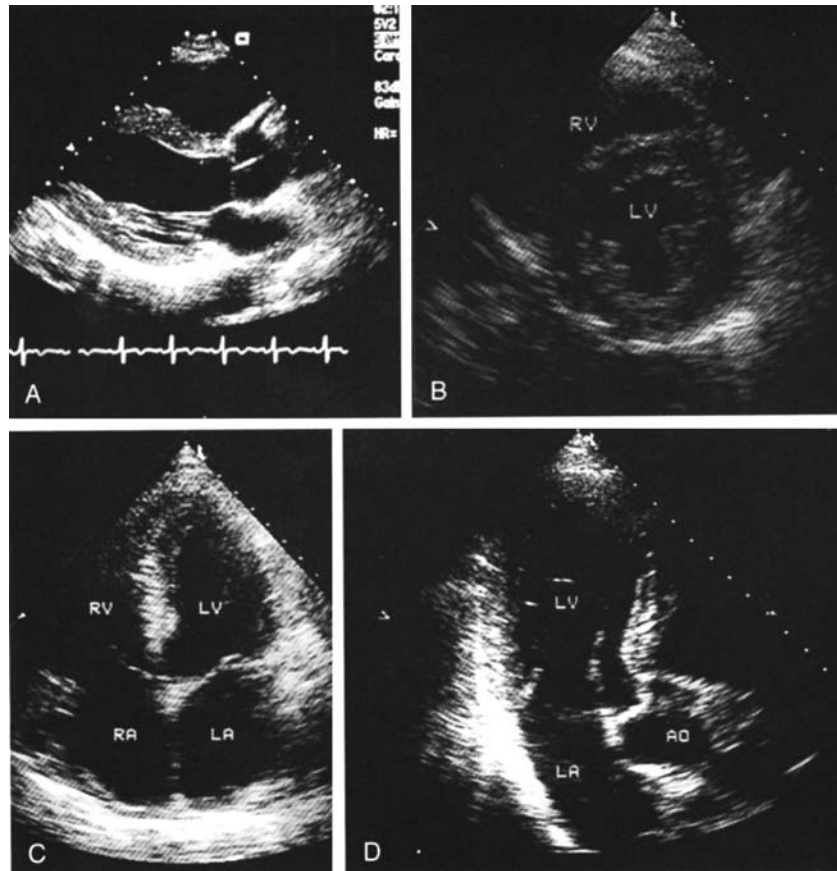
(A) Two-dimensional image of the heart in the parasternal long-axis view. (B) Short-axis plane through the heart at the level of the papillary muscle. (C) Two-dimensional image of the apical four-chamber plane. (D) Two-dimensional image of the apical three-chamber plane. (From Rosendorff, C., *Essential Cardiology*, Philadelphia: W. B. Saunders, 145, 2001.)
